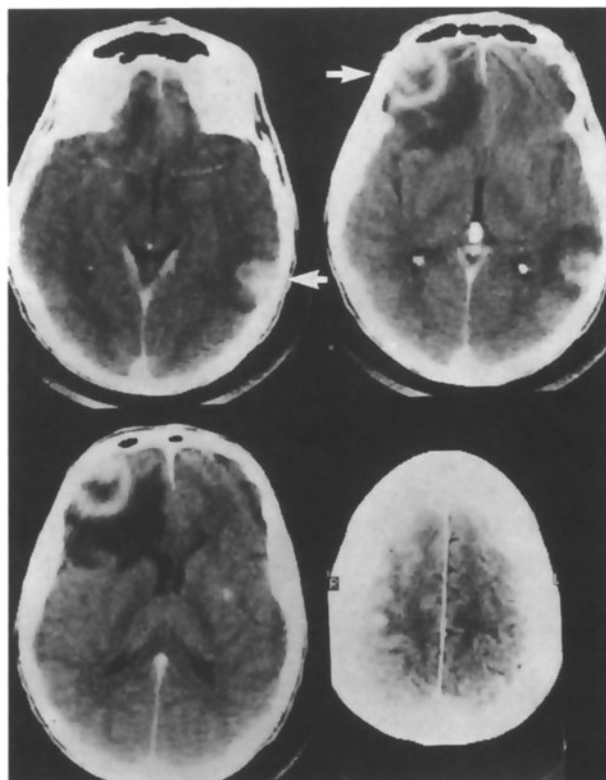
CT scan from the patient in Fig. 8 reveals multiple and bilateral contrast-enhancing brain abscesses surrounded by edema. This presentation is seen in *T. gondii* infection more often than the large solitary lesions often associated with CNS lymphoma.
